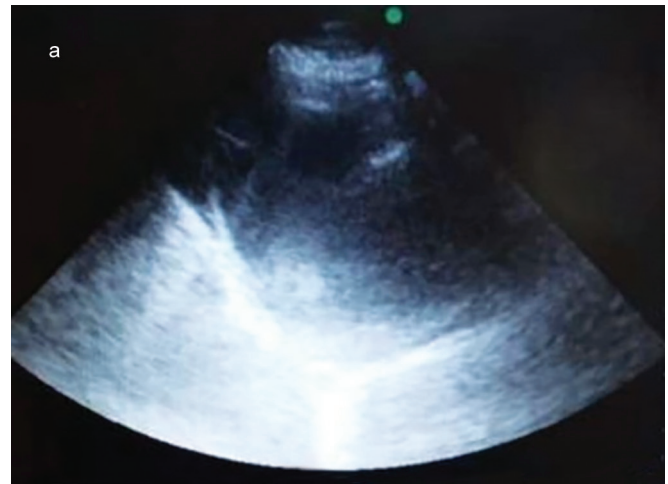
Ultrasound thorax showed a unilocular rounded well-defined hypochoic lesion on normal breathing
